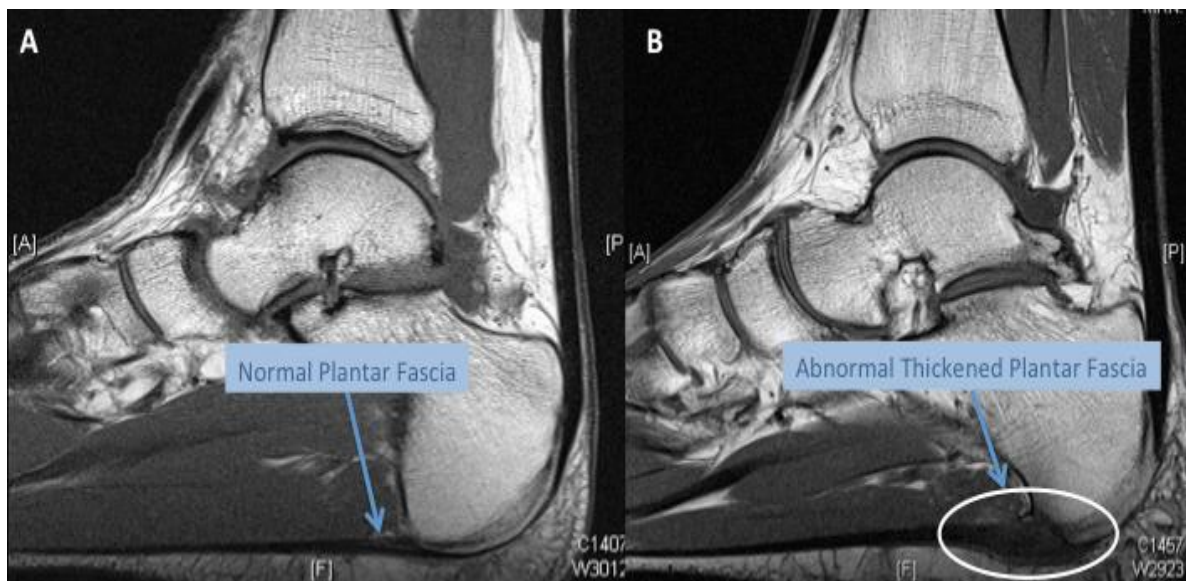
(A) MRI showing Normal Plantar fascia; (B) MRI showing Thickened Plantar fascia.
